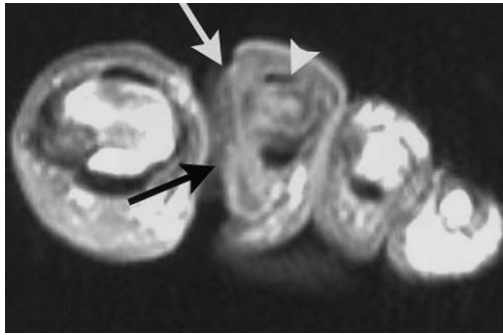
Coronal T1-weighted (T1W) scan
